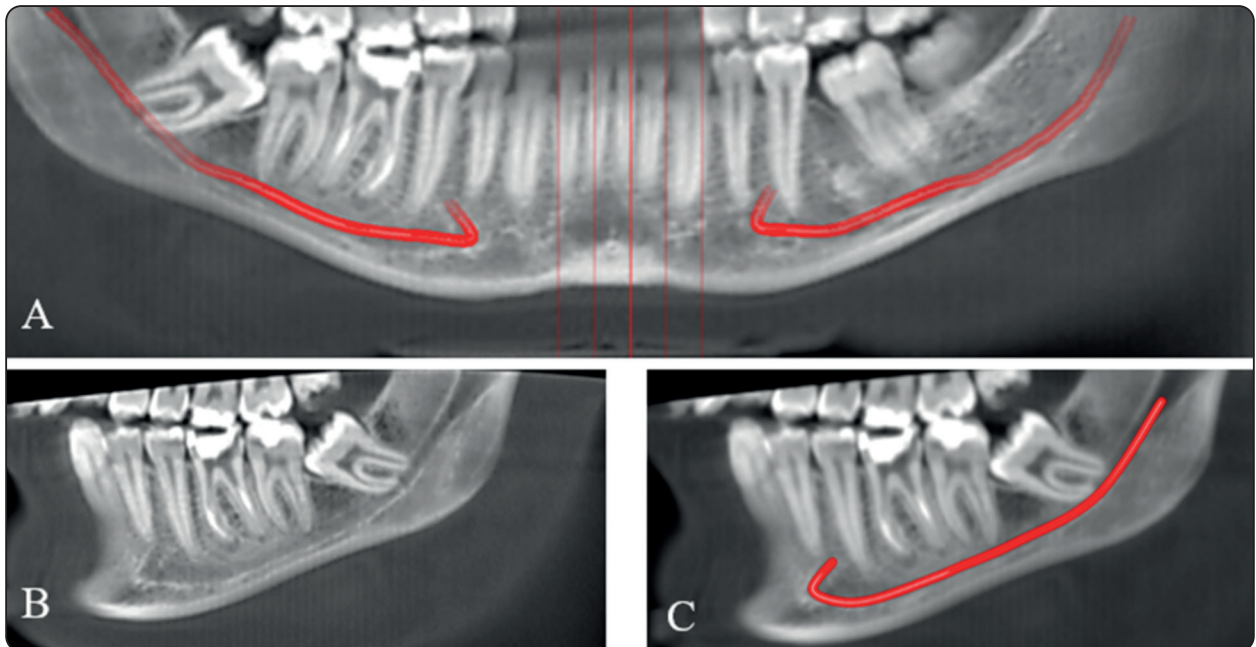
CBCT images, A: Reformatted panoramic view, B and C; Sagittal views showing the anterior loop (AL) of the inferior alveolar nerve (IAN).
